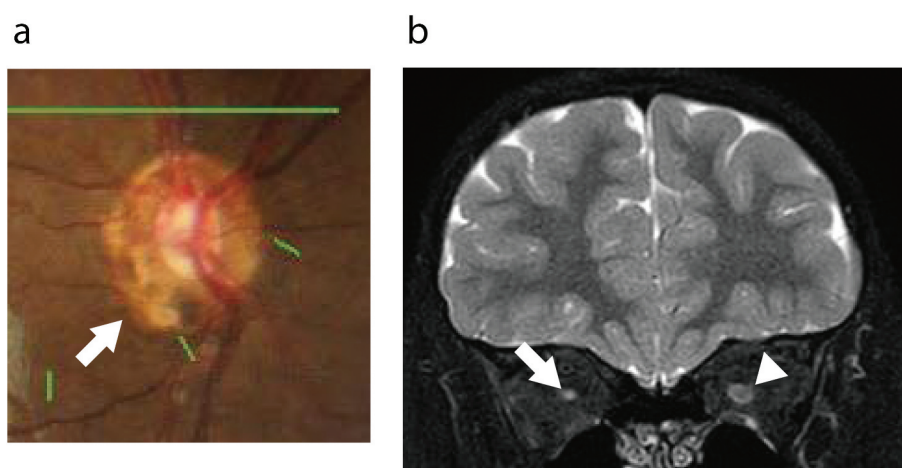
Fundus photograph (a) and coronal MRI (b) of a patient with ONH (Number 10). (a) Both a small papilla and a double-ring sign (white arrow) are observed. (b) The right optic nerve (white arrow) is very thin compared with the normal left optic nerve (white arrowhead).
